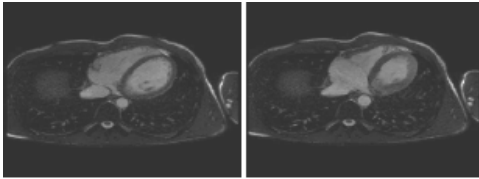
Isotropic MRI images at same slice for vol01. Phase 1 (left) and Phase 14 (right) are shown here.
